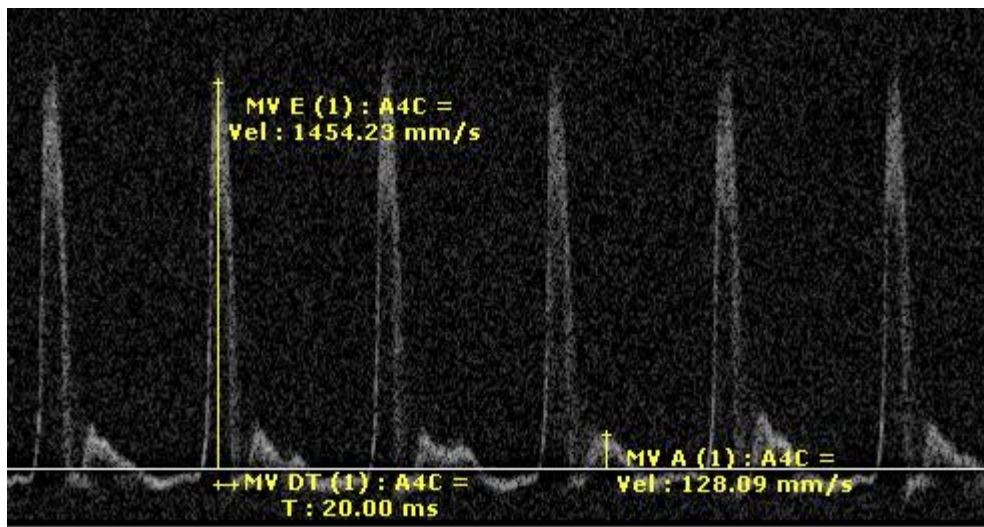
Doppler spectra of mitral inflow obtained from 4 chamber view.
